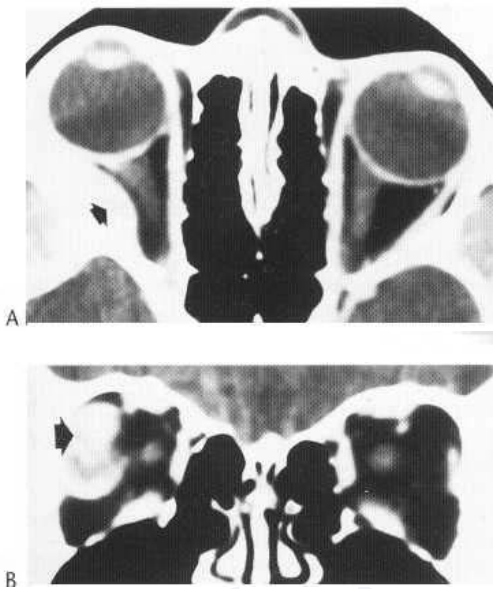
Myositic pseudotumour. Enhanced axial (A) and coronal (B) CT images demonstrate fusiform enlargement of right lateral rectus muscle (arrowheads).
